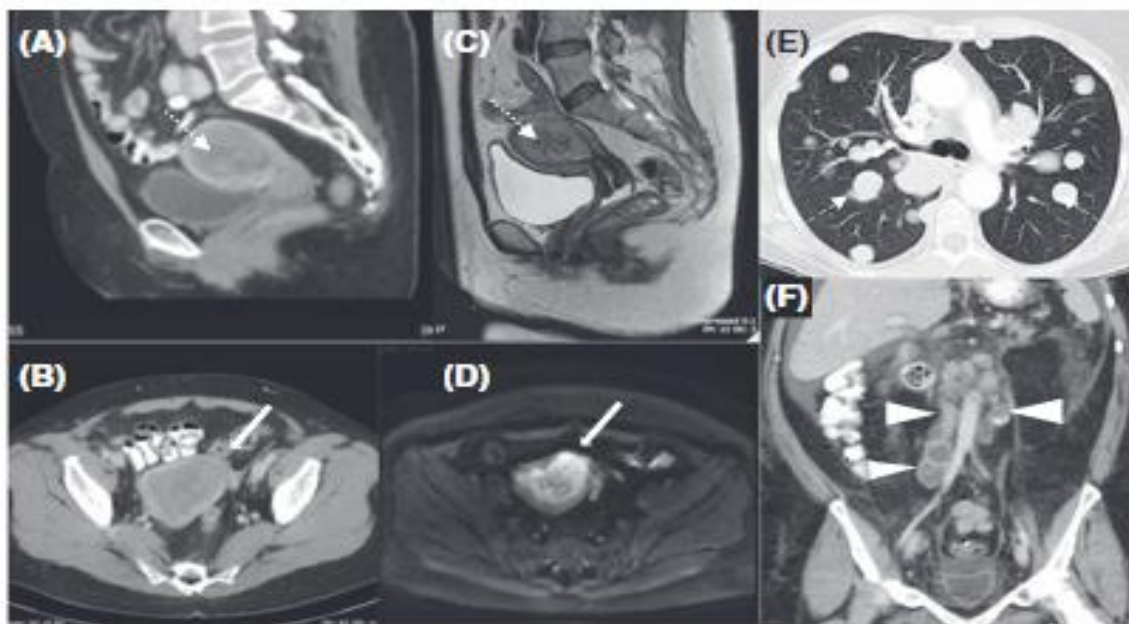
Computed tomography (A: sagittal plane, B: axial plane) and MRI (C: sagittal T2, D: axial diffusion-weighted) in the same patient with endometrial carcinoma. (E) Axial CT scan showing lung metastases (arrowheads). (F) Coronal CT scan showing pelvic and abdominal metastases (arrowheads).
